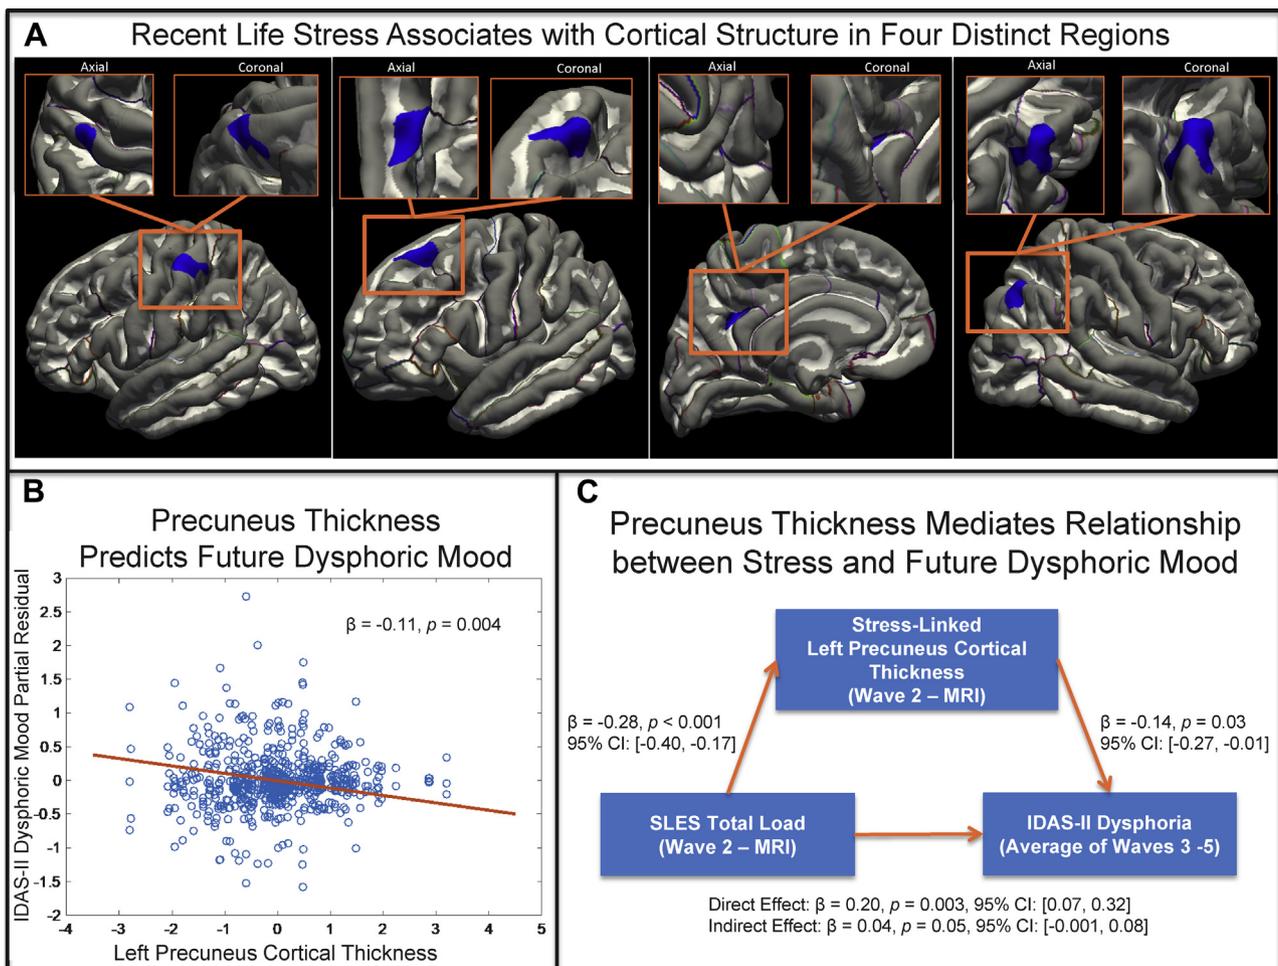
(A) Surface-based morphometry results surviving multiple comparisons correction for the stress analysis (clusterwise $p_{corrected} < .05$). Thinner left postcentral associated with more stress (left region). Smaller left superior frontal associated with more stress (left-center region). Thinner left precuneus associated with more stress (right-center region). Smaller right inferior parietal associated with more stress (right region). (B) Partial residual for Inventory of Depression and Anxiety Symptoms II (IDAS-II) Dysphoria scores across waves 3–5 as estimated from the linear mixed model accounting for age, wave, wave², IDAS-II dysphoria score at the time of imaging (wave 2), and the stress-linked left precuneus cortical thickness estimate. Resulting model standardized β for the fixed effect of precuneus cortical thickness shown and resulting p value. (C) Mediation results shown for x = Stressful Life Events Schedule (SLES) total load, M = stress-linked left precuneus cortical thickness, and y = IDAS-II dysphoria score over waves 3–5. Standardized model β , p values, and 95% confidence intervals (CIs) shown. MRI, magnetic resonance imaging.
